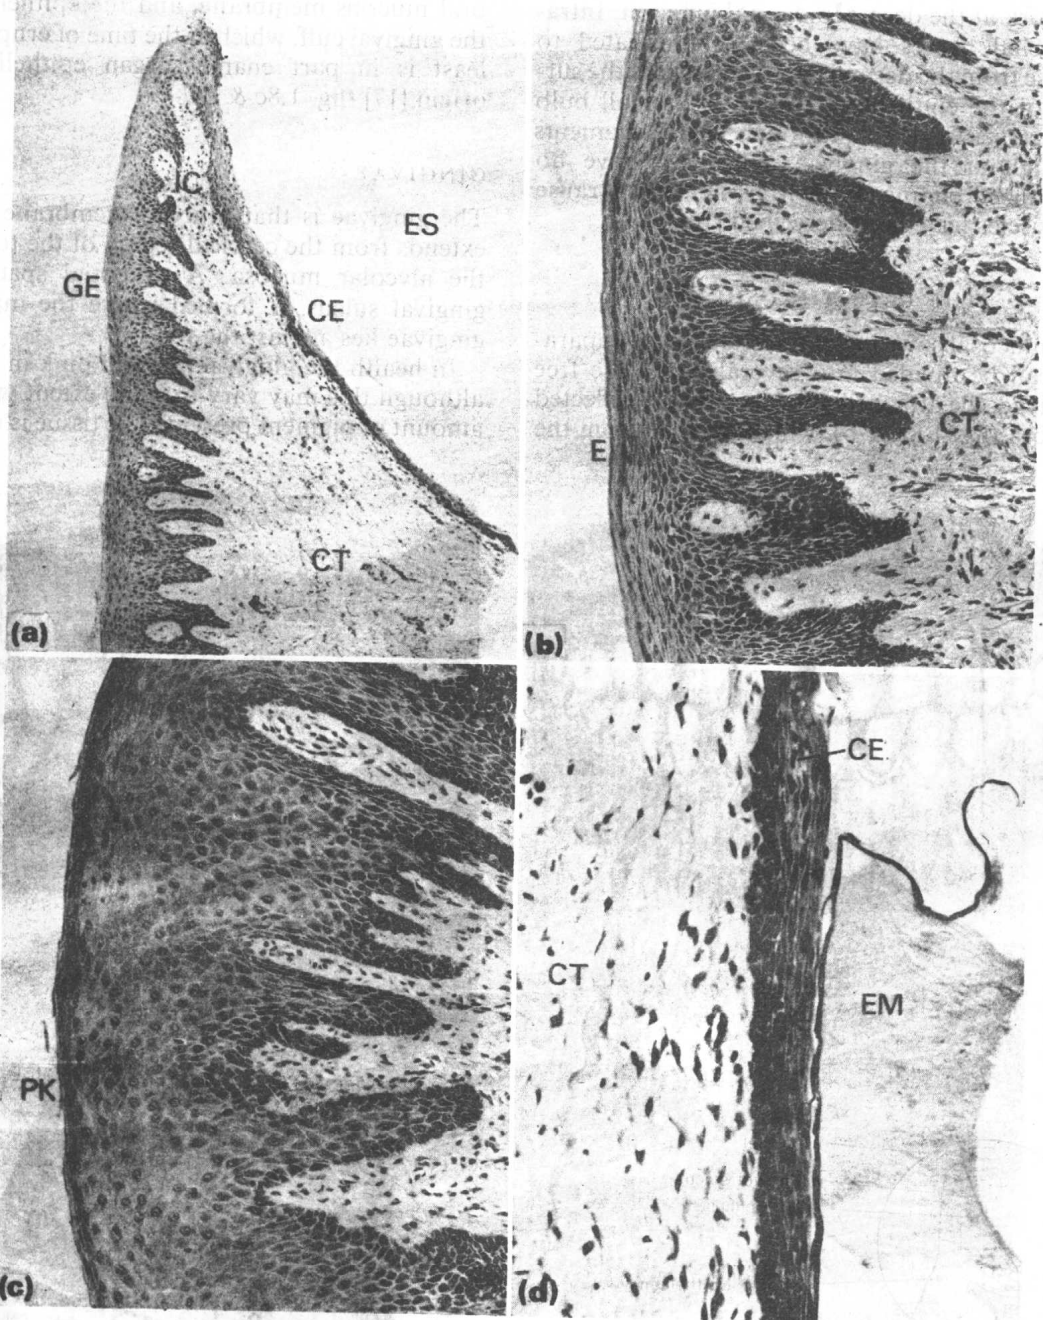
(a) Buccolingual section through clinically healthy gingival cuff; CE, cuff epithelium; CT, connective tissue; ES, enamel space; GE, gingival epithelium; IC, inflammatory cells, present even in clinically healthy gingiva. (b) Section of gingival epithelium with underlying connective tissue (CT); epithelium (E) shows keratinization (orthokeratinization). (c) Section of gingival epithelium showing parakeratinization (PK), i.e. presence of nuclei in keratinized layer. (d) High power of healthy cuff epithelium (CE) which is non-keratinized. Note the close relationship to the enamel matrix (EM) and the absence of inflammatory cells in the connective tissue (CT).
